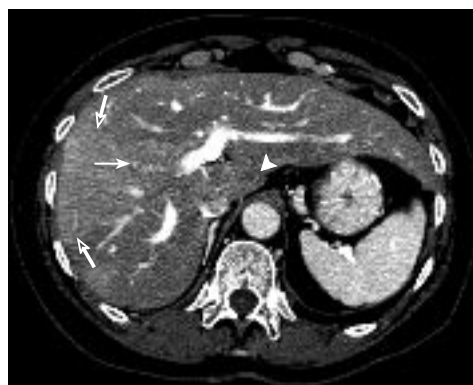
Contrast enhanced CT at the level of the portal bifurcation after treatment shows improved hepatic metastasis in segment I (arrowhead), non-visualization of the thrombosed anterior right segmental portal vein (arrow), opacified posterior segmental portal veins, middle and right hepatic veins, and wedge shaped increased enhancement (open arrows) of the anterior sector secondary to portal vein occlusion.
